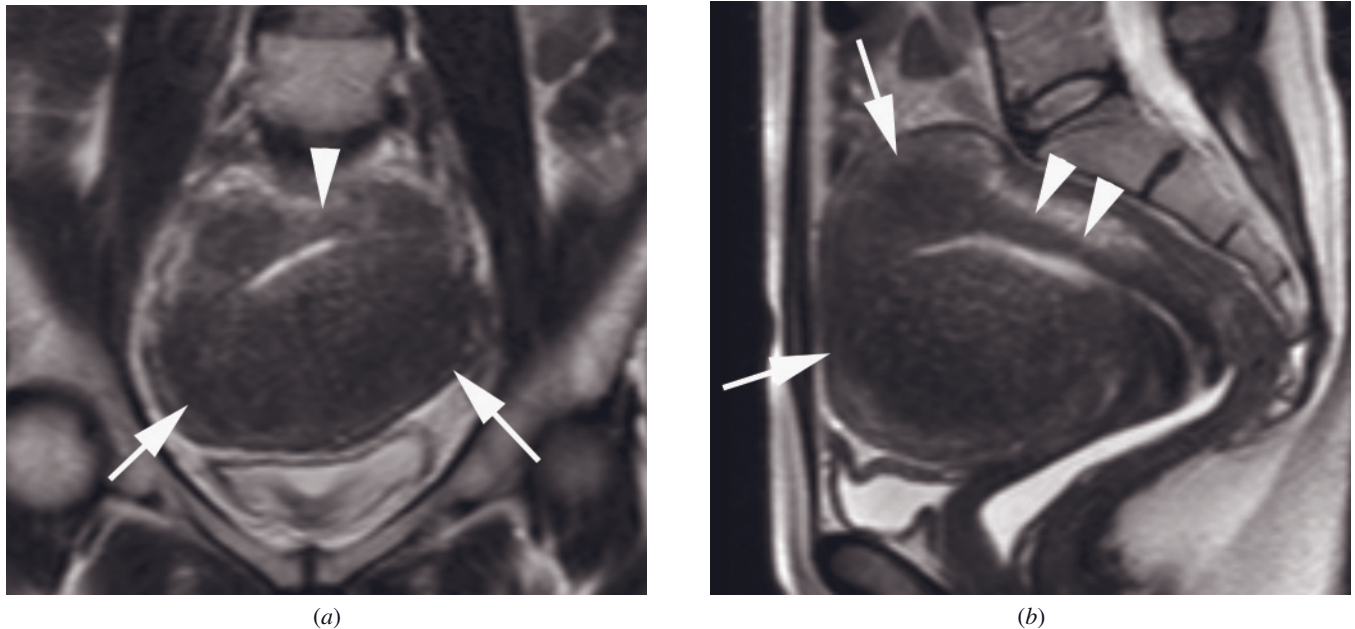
Diffuse asymmetric adenomyosis. Coronal (a) and sagittal (b) T2-weighted ETSE images show a markedly thickened junctional zone with greater involvement of the anterior uterus (arrows) and a small area of sparing in the posterior uterus where the junctional zone is nearly normal (arrowheads). Diffuse adenomyosis frequently has an asymmetric distribution. Note the punctate high signal foci throughout the lesion.
